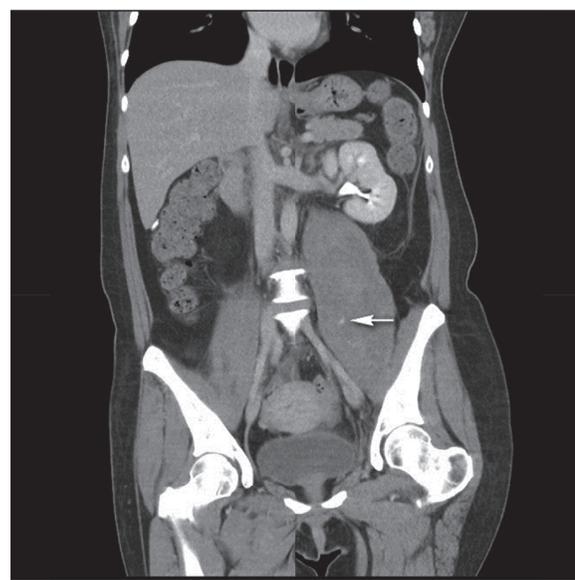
Computed tomography scan of abdomen showing left iliopsoas muscle hematoma with active bleeding (arrow).
